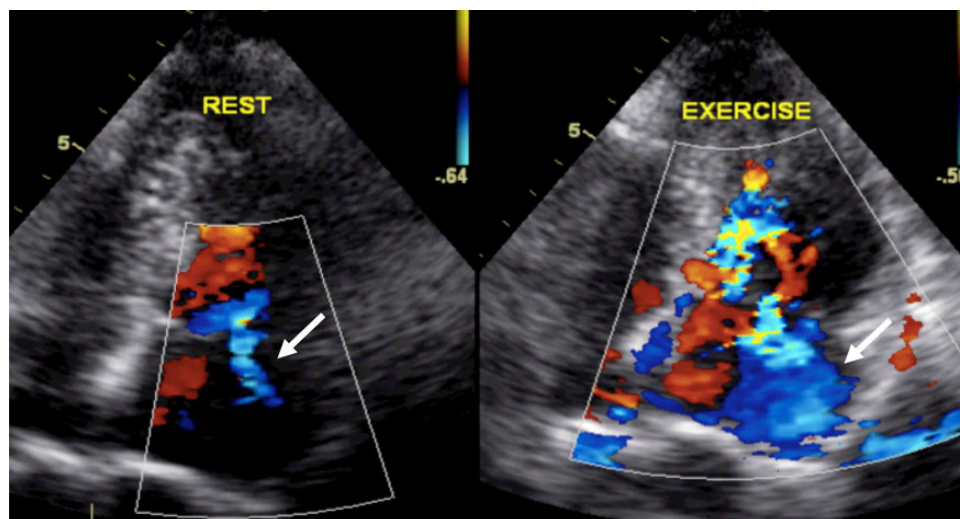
Significant increase in mitral regurgitation during exercise echocardiography (mild at rest and severe at exercise) in a patient with HCM.
